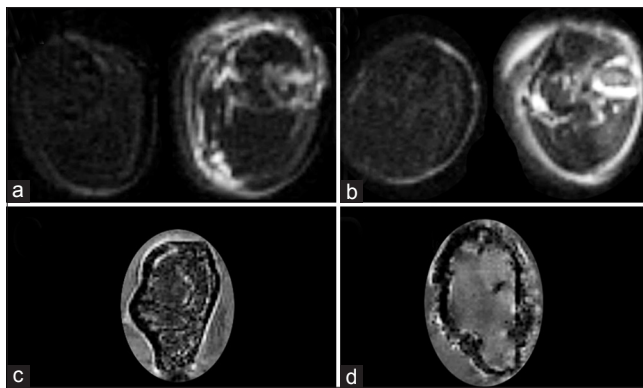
Joint inflammation and bone destruction. T2-weighted MRI indicating edema in contralateral (left) and ipsilateral (right) stifle joint one week after mineral oil (a) or CFA (b) injection. FLASH-based MRI of femurs after intramedullary injection of PBS (c) or NCTC cells (d) three weeks earlier. CFA: complete freund adjuvant; MRI: magnetic resonance imaging; PBS: phosphate buffer saline
